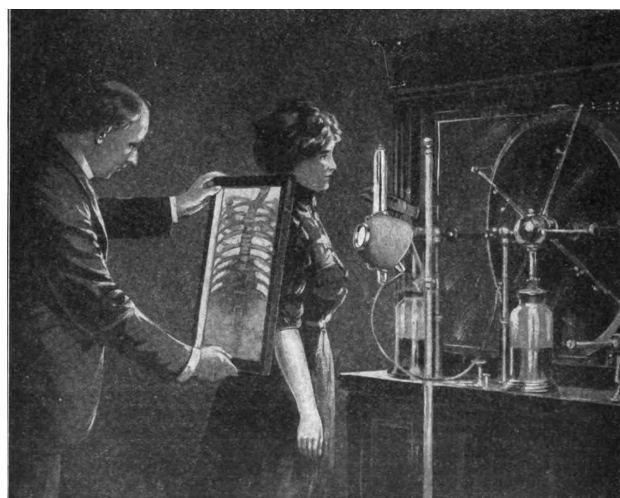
Early application of fluoroscopy. The useful beam is directed on the patient and radiologist who observes the X-ray projection on a fluorescent plate. No precautions for radiological protection were taken. [18, p. 6]
